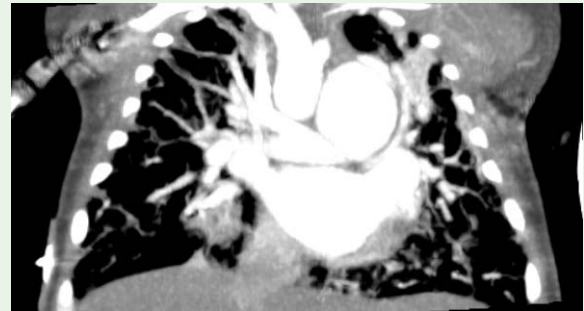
CT cardiac angiogram showing large arterial duct aneurysm (PDA).
